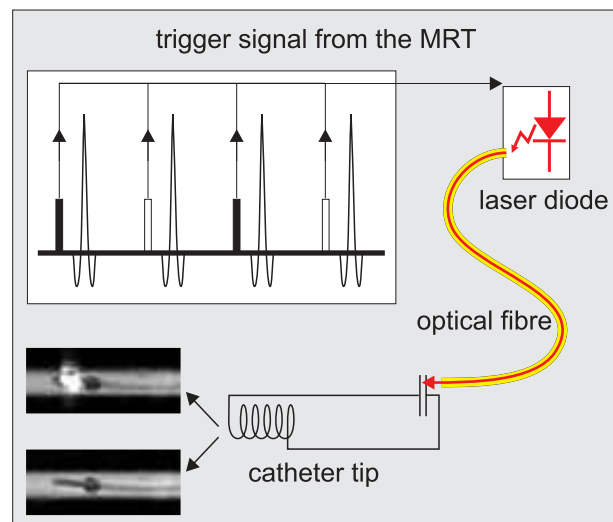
Automatically triggering of the resonant circuit by the MR imaging tool and MR images of the catheter-tip tuned and detuned to the excitation frequency.
